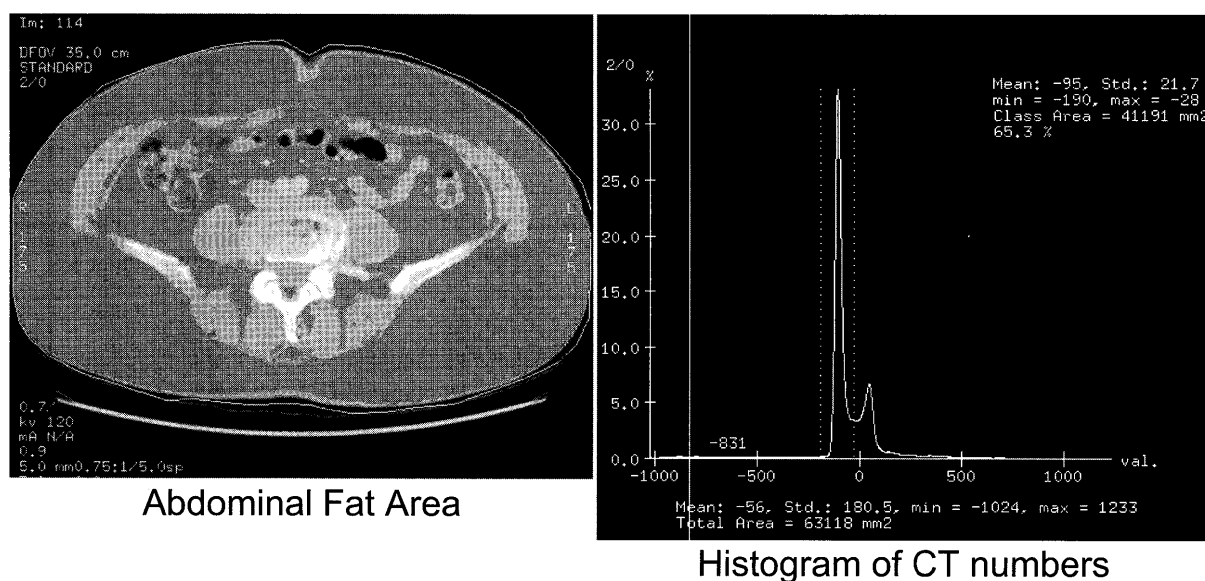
Images obtained preoperatively with 4 lines multi-slice CT: GE Light Speed QX/i-d (General Electric, Milwaukee, WI) were re-established on the image software: GE. Advantage Workstation 4.0, Volume Analysis (General Electric, Milwaukee, WI). One axial slice of CT images at the umbilical height was analyzed for this study with the conventional method^{9~11)}. CT numbers in Hounsfield units from -190 to -30 which indicate the fat CT density was extracted, and AFA was calculated with the software (Fig. 1). Then the body fat mass was estimated with the following Despres's equation: $TBF = 0.05234 \times AAT + 2.8788$ in adult males, $TBF = 0.0593 \times AAT + 1.6589$ in adult females (TBF: total body fat, AAT: abdominal adipose tissue)¹²⁾. FFM was calculated by reducing the body fat mass from actual body weight: $FFM (kg) = BW (kg) - TBF (kg)$ (BW: body weight).
